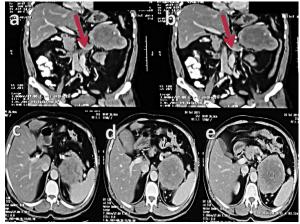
(a and b) Computed tomography scan with coronal view. Arrows demonstrate tumor thrombus extension into the left renal vein; (c, d and e) computed tomography with axial view demonstrating large heterogeneous adrenal lesion.
